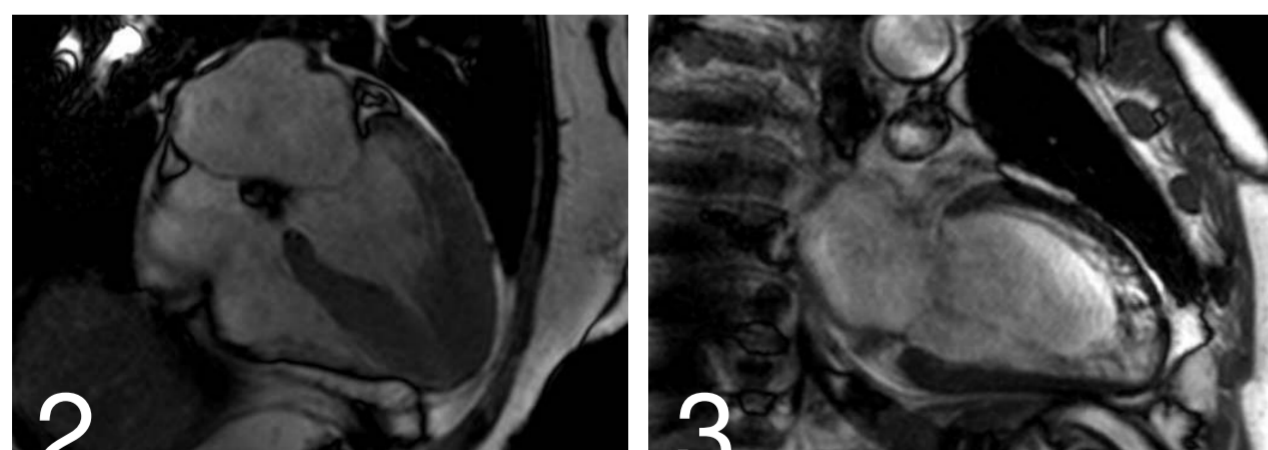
Systolic image from a cardiac magnetic resonance imaging cine in a 4-chamber plane, depicting an apical hypertrophic cardiomyopathy with hypertrophy of the apical segments and an ace-of-spades morphology.
